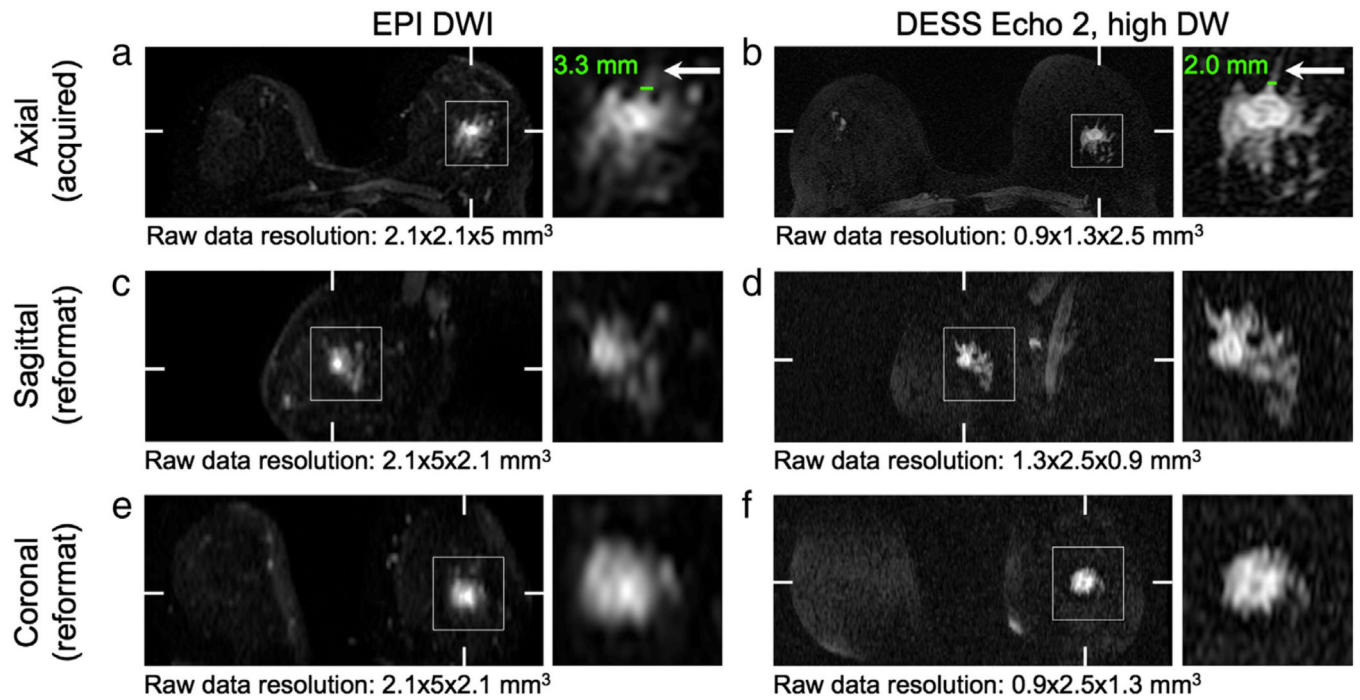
Reformatted images. The images acquired with the DESS sequence (b, d, f) have higher resolution than those acquired with the EPI DWI sequence (a, c, e), which is particularly evident in the images reformatted in the sagittal plane (c, d). The higher resolution allows for better depiction of fine features (arrows). Hash marks indicate the locations of the reformatted planes. Detail shows a grade 2 invasive ductal carcinoma.
